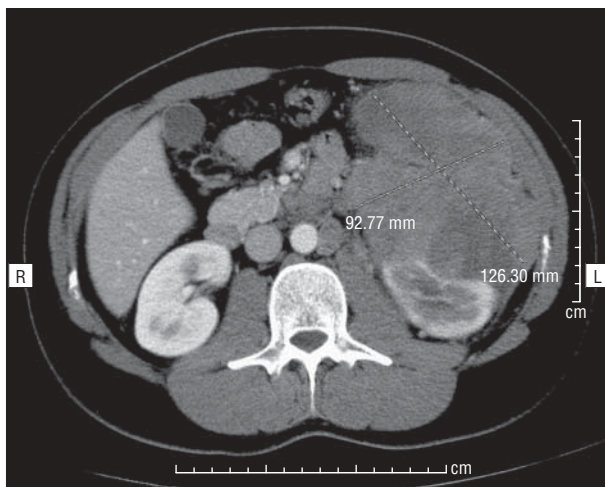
Abdominal computed tomographic scan showing a 12.6 \times 9.3-cm mass with central necrosis occupying almost the entire left hypochondrium and flank. L indicates left; R, right.
